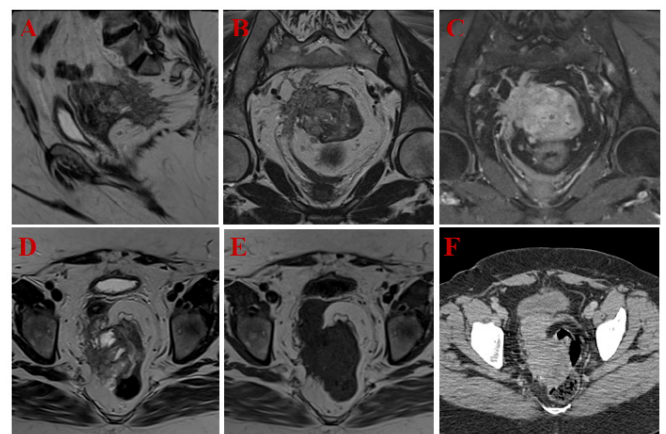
Pelvic MRI in 2025, reported as possible locally advanced rectal tumour. (A) (sagittal T2) shows the presumed rectal lesion, appearing to involve the posterior wall of the uterus and right pelvic side wall, with further views shown in (B) (coronal T2), (C) (contrasted enhanced coronal T1), (D) (axial T2) and (E) (axial T1). High T2 signal, best shown in (D), was interpreted as mucinous component of tumour. (F) shows the soft tissue mass demonstrated in 2008; unchanged in size compared to the 2025 MRI.
